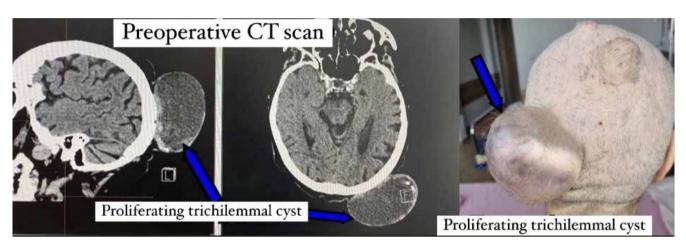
Preoperative status; MRI has found evidence of three subcutaneous tumor masses suspicous for trichilemmal cysts.
